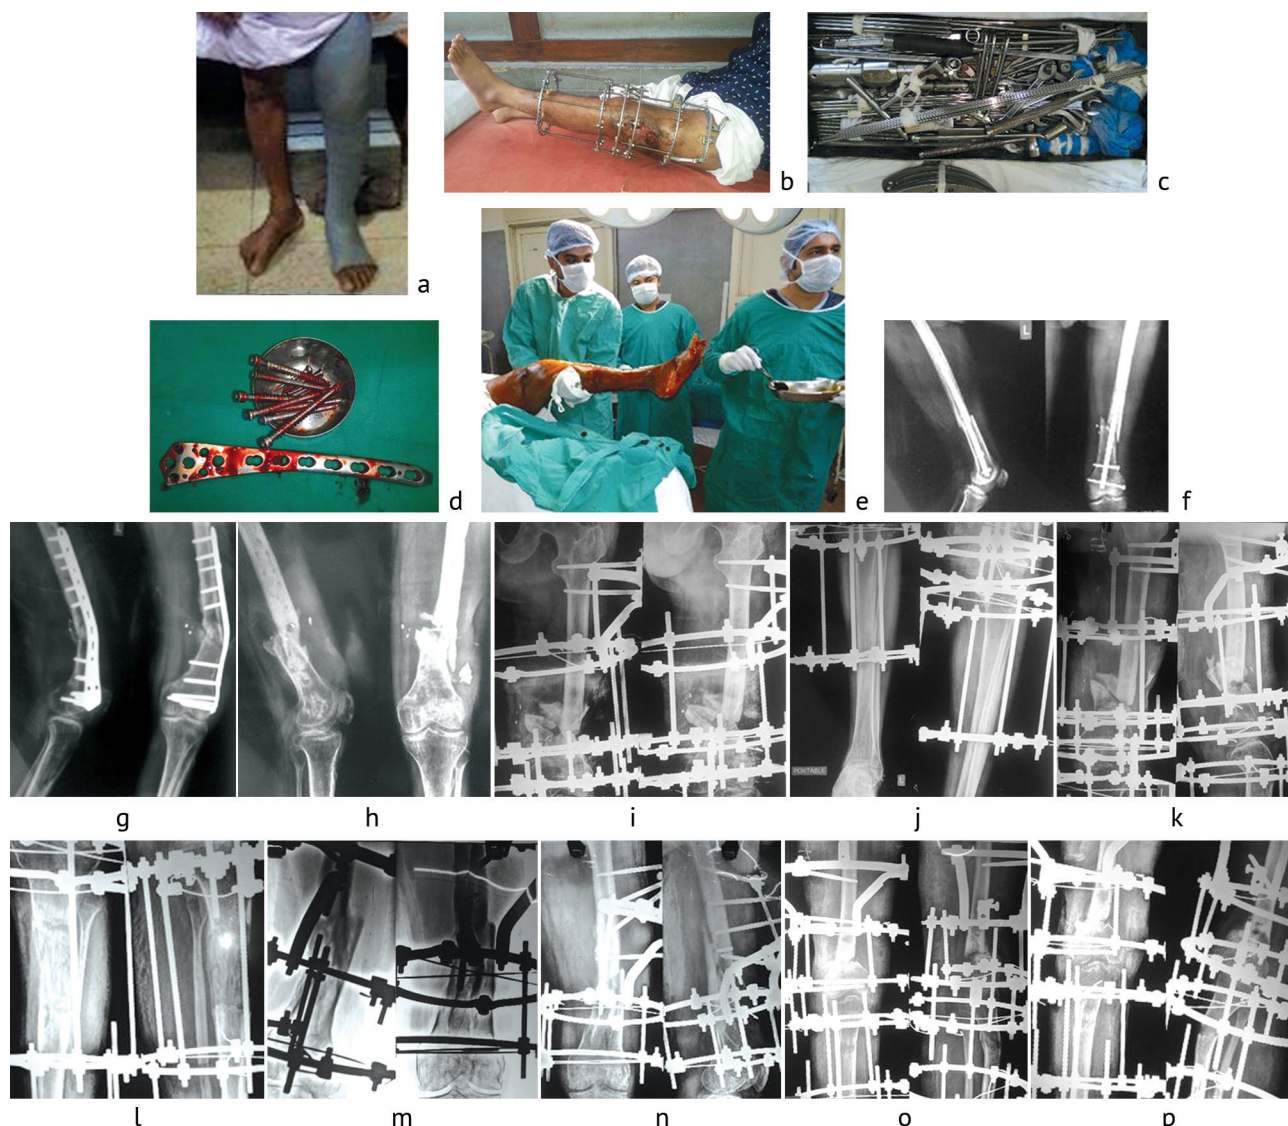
a* patient with long leg cast after removal of Ilizarov rings; *b* patient with Ilizarov frame; *c* instruments set; *d* removed infected implants; *e* surgical team; *f* x-ray of nonunion with intramedullary nail; *g* plate failure with infection; *h* preoperative x-ray; *i-j* immediate postoperative x-ray; *k* postoperative follow up x-ray; *l* corticotomy and lengthening; *m-p* postoperative x-rays of different patients
